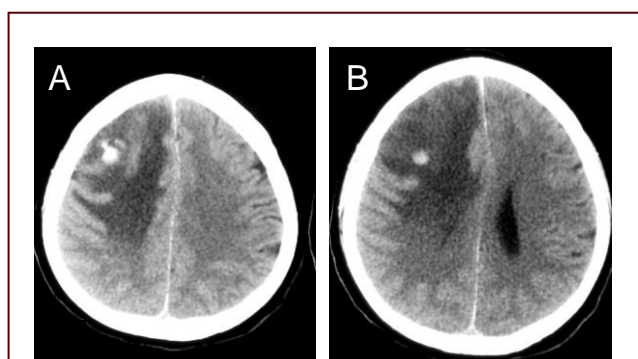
Cerebral CT of a patient with isolated cortical vein thrombosis.
